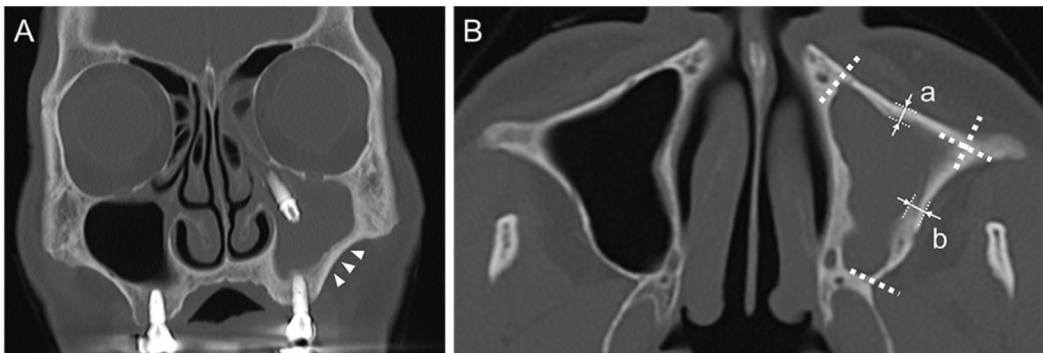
Computed tomographic image for maxillary sinus wall thickening suspected to be osteitis (A, arrowheads) and measurements of sinus wall thickness (B). a, thickness of anterior sinus wall; b, thickness of lateral sinus wall; dotted line, reference lines for determining midpoints of anterior and lateral sinus walls.
